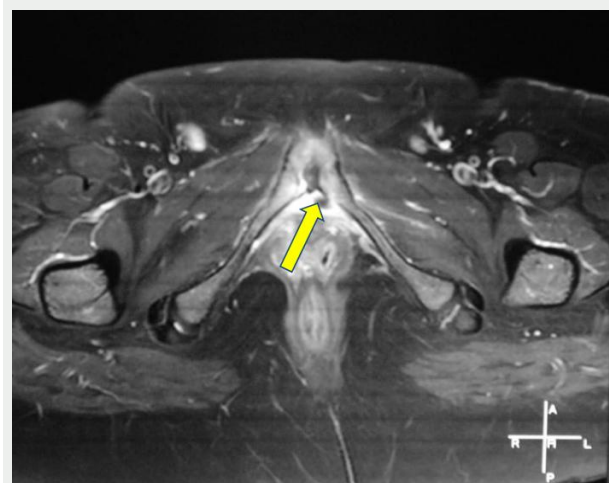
Pelvic MRI showing an intra-articular collection at the pubic symphysis
